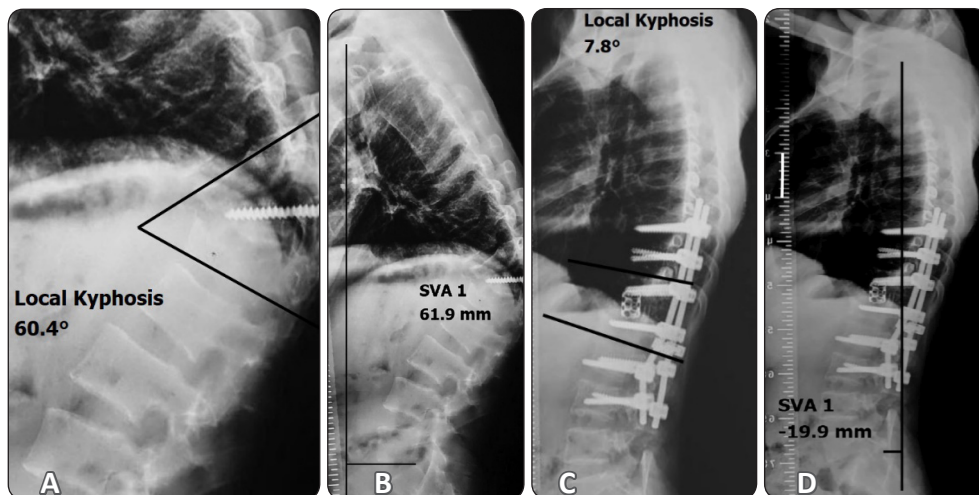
Patient No., 12, 37-year-old male with post-traumatic kyphosis at T12. (A) Preoperative lateral radiographs show the local kyphotic deformity 60.4°. (B) Preoperative sagittal imbalance of 61.9mm. (C) Postoperative local kyphotic angle correction to 7.8°. (D) Postoperative sagittal vertical axis correction to 19.9mm.
